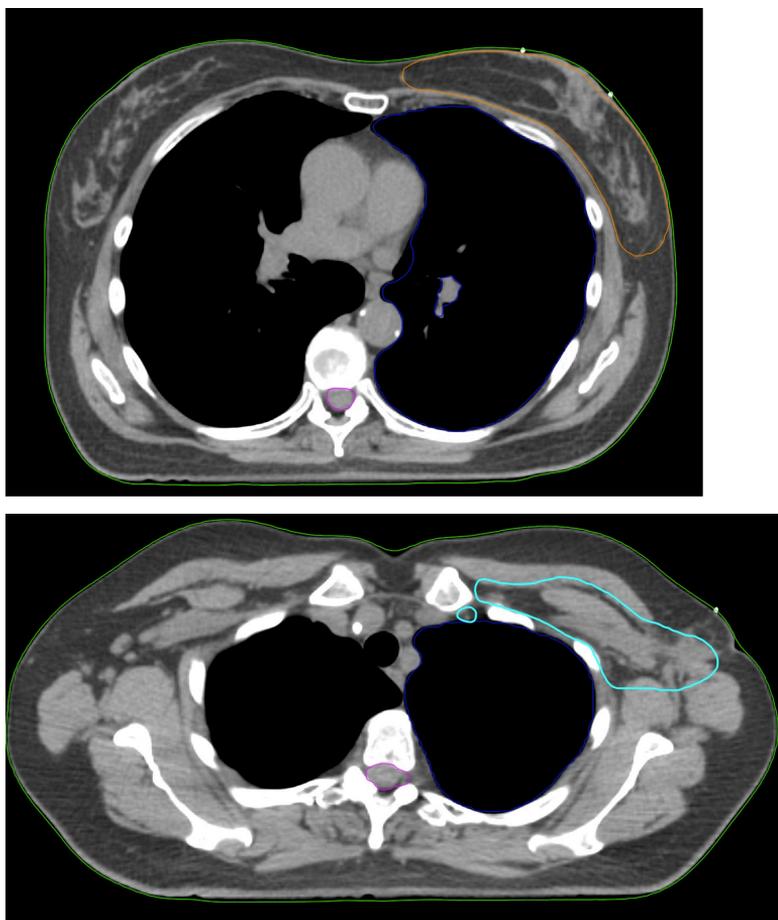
A) The clinical target volume (CTV) of the breast tissue contoured to planning CT slice (orange) B) CTV of the lymph node regions above the sternum level (interpectoral, axilla III, internal mammary lymph node regions; cyan).
